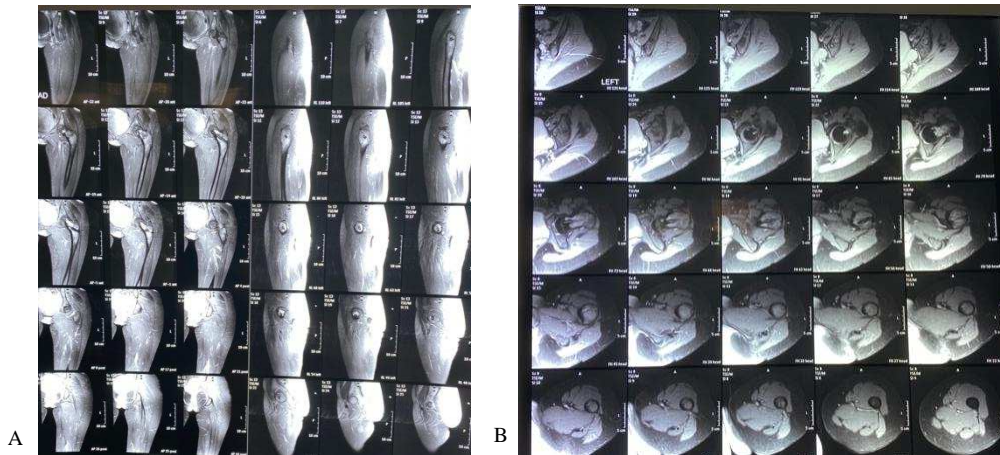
(a) MRI on coronal and sagittal section with contrast; (b) MRI on axial section with contrast
